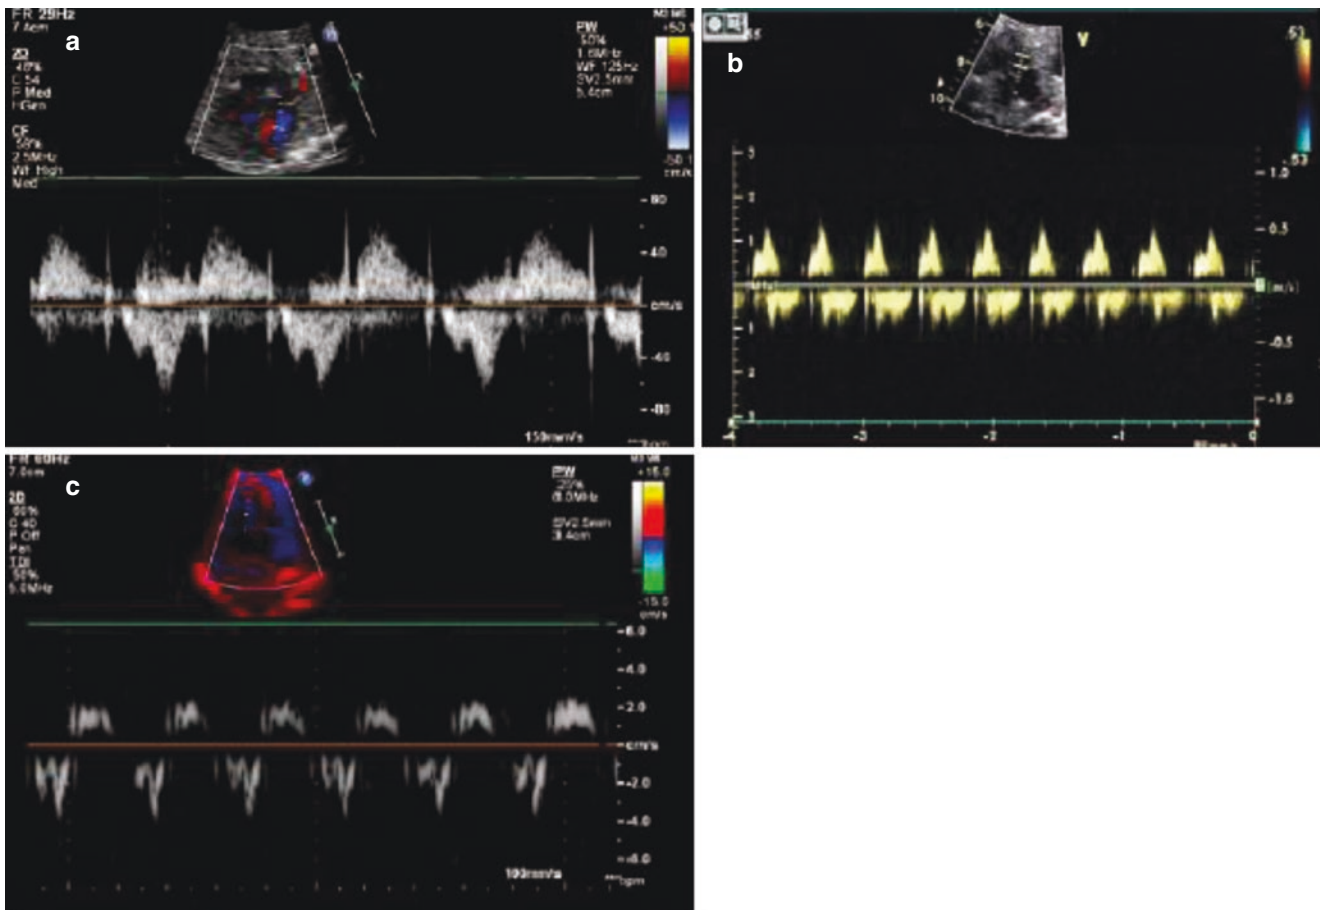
Pulsed Doppler and tissue Doppler echocardiography images. (a) It shows A wave, the atrial excitation wave, when the PW samples are placed at the adjacent areas of the inflow and outflow tracts of the left ventricle. (b) PW is sampled at PA and PV, showing normal
